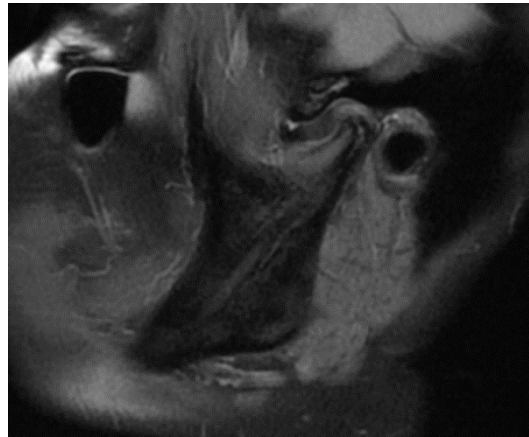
PD MRI of the right temporomandibular joint in the sagittal plane with an altered closed mouth articular disc, thickened posterior band disc shape, and anterior disc position to the mandible condyle.
